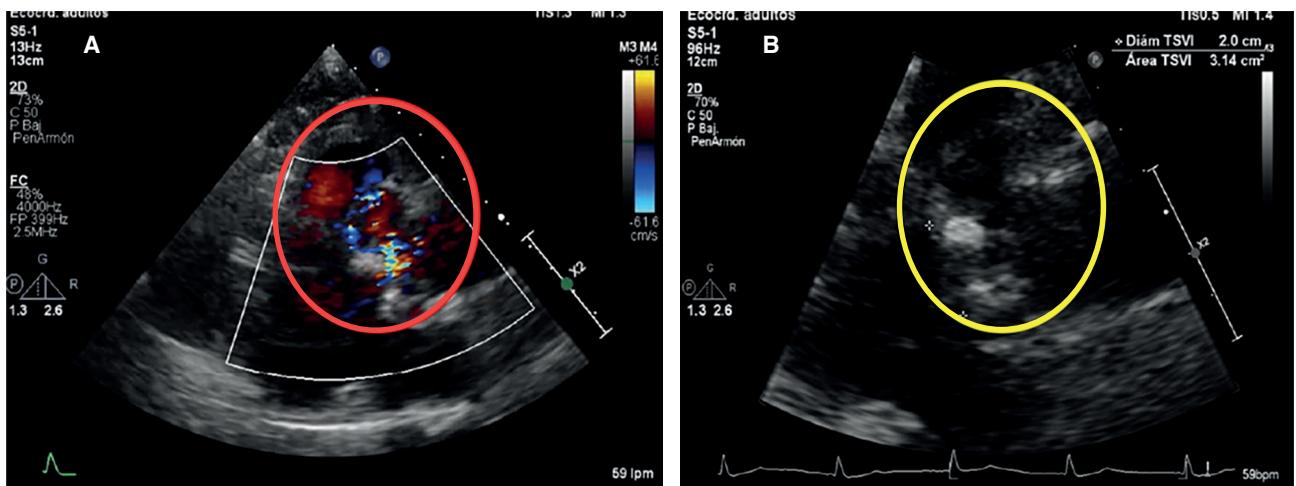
A) Dilatation of the sinus of Valsalva observed via color Doppler. B) Transthoracic echocardiogram image.
